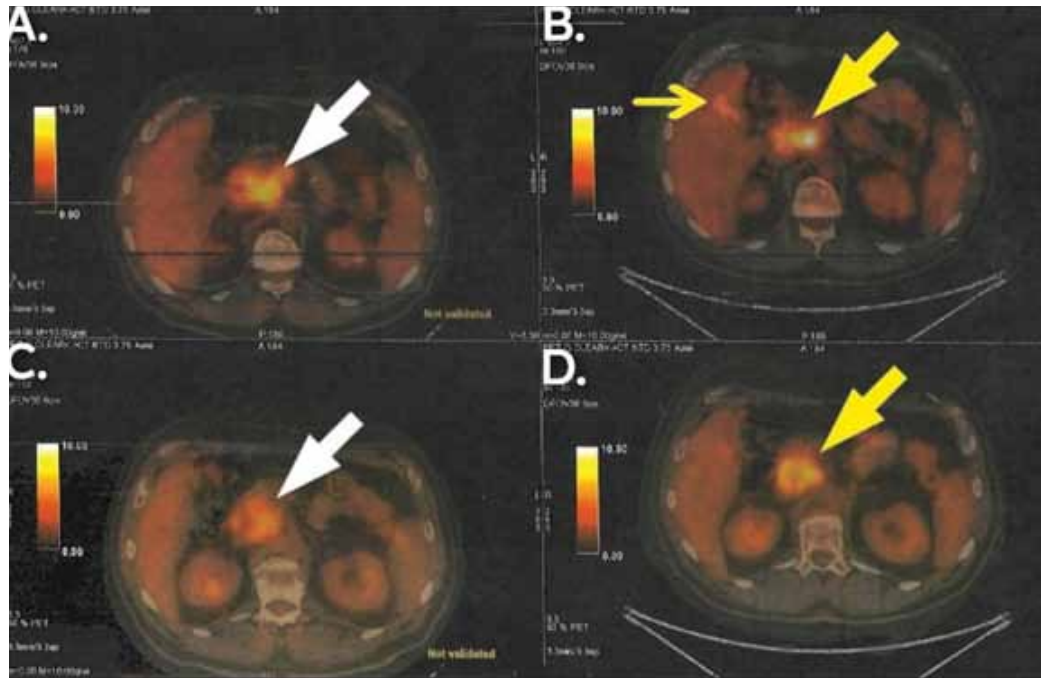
PET/CT showing the findings after the first and the second schemes of adjuvant therapy and their relapses, respectively (B and D show the first relapse and A and C show the second relapse). Enlarged paraaortic lymph nodes and a mass in the lumen of the right colic flexure (big and small yellow arrow in B) and enlarged lymph nodes behind the margin of the head and body of the pancreas (big yellow arrow in D) were findings of the first relapse. Further enlarged paraaortic lymph nodes with higher SUVmax (big white arrow in A) and further enlarged posterior pancreatic lymph nodes, behind the margin of the head and body of the pancreas, (big white arrow in C) were findings of the second relapse.
